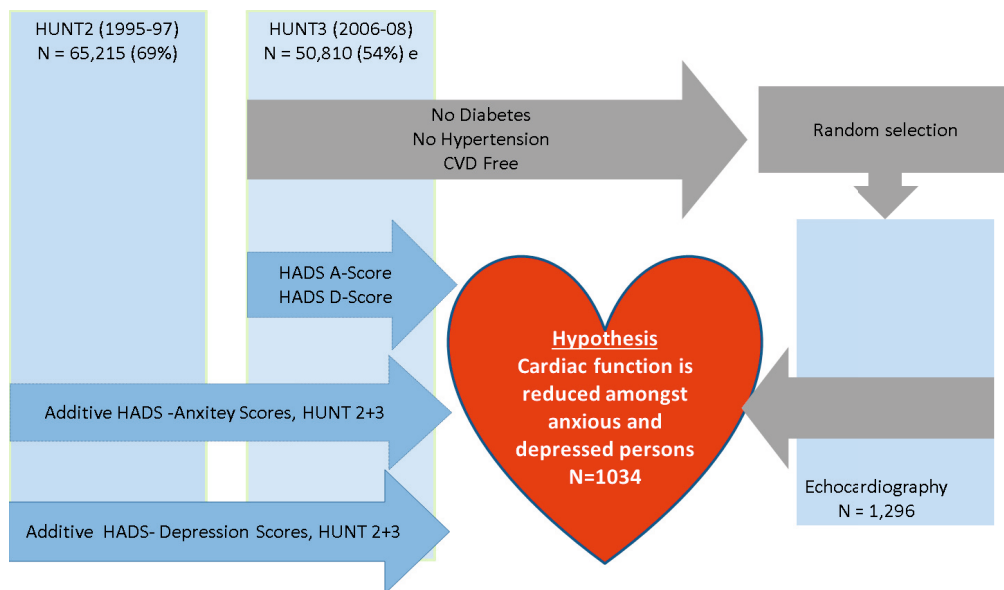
Sources of selection for the echocardiography study and data extraction for one and two reports of anxiety and depression symptoms.
